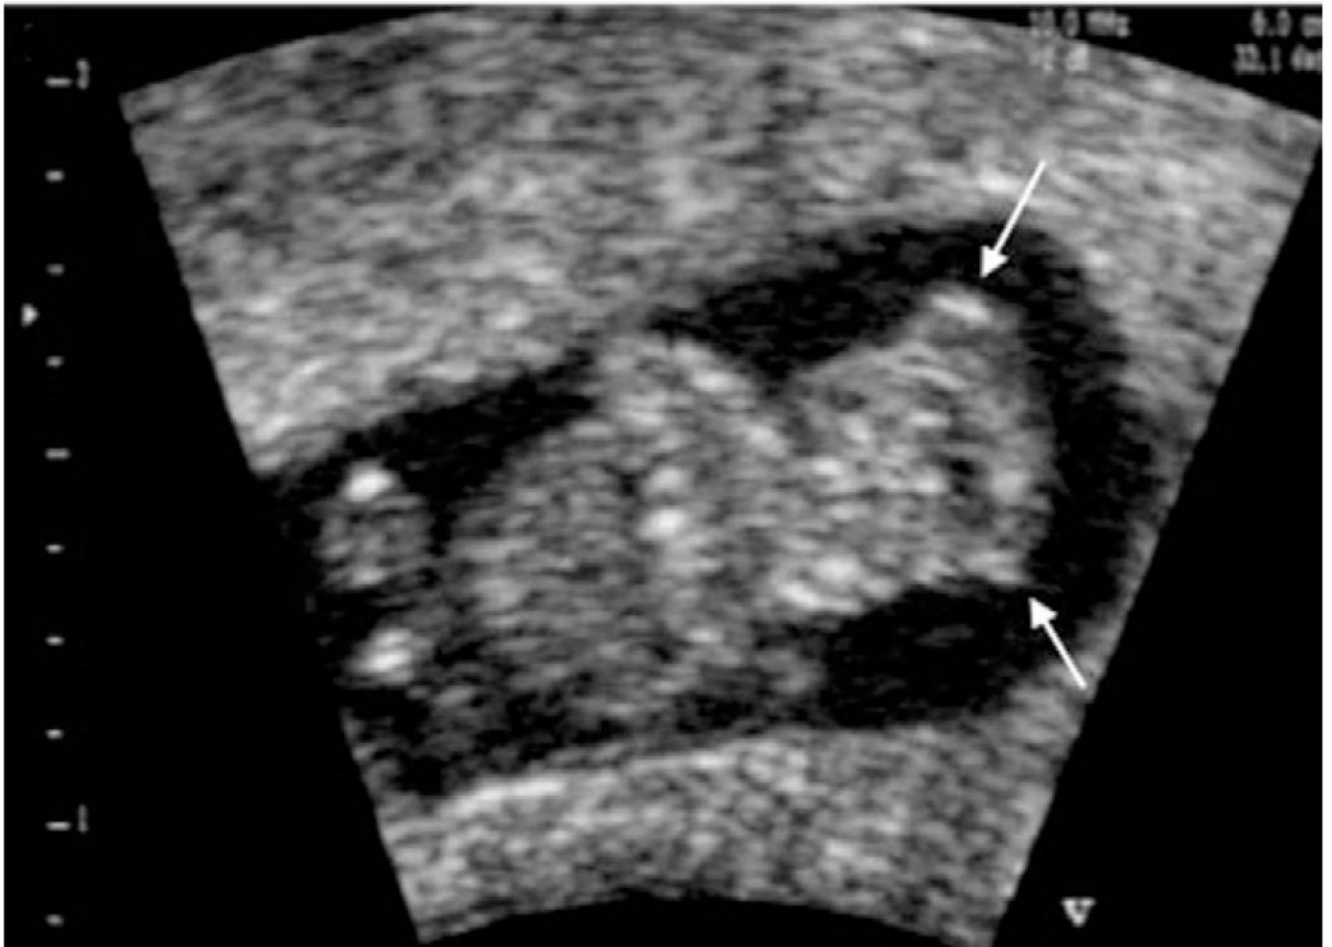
Two-dimensional ultrasonic scanning of exencephaly in the first trimester. The contours of the brain are irregular (arrows). Modified with permission from; Blaas HG, Eik-Nes SH. Sonoembryology and early prenatal diagnosis of neural anomalies. *Prenat Diagn* 2009;29:312–25.
